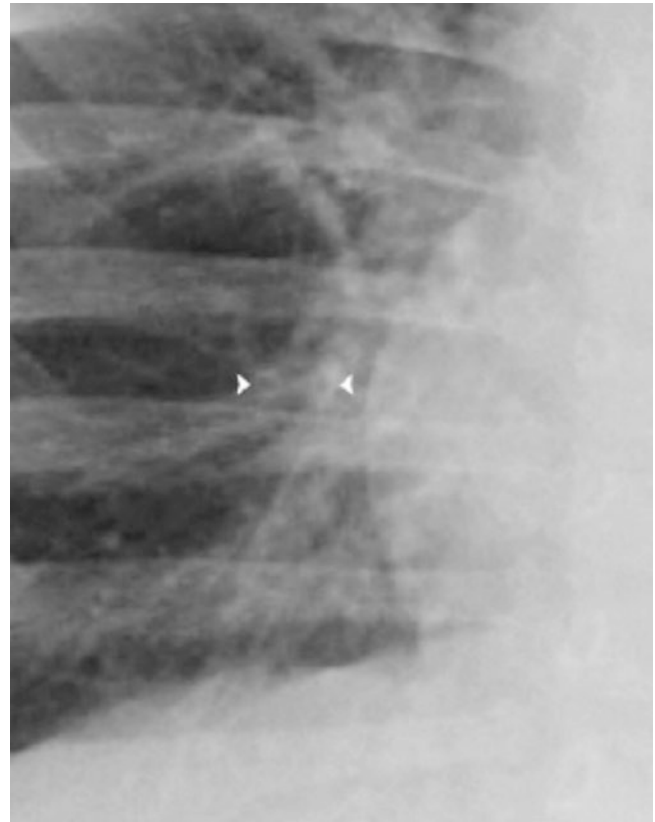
This magnified view of the chest of an 8-month infant with severe respiratory distress demonstrates the radiographic finding of peribronchial cuffing. The margins of the bronchus (*arrowheads*) are thickened and irregular
